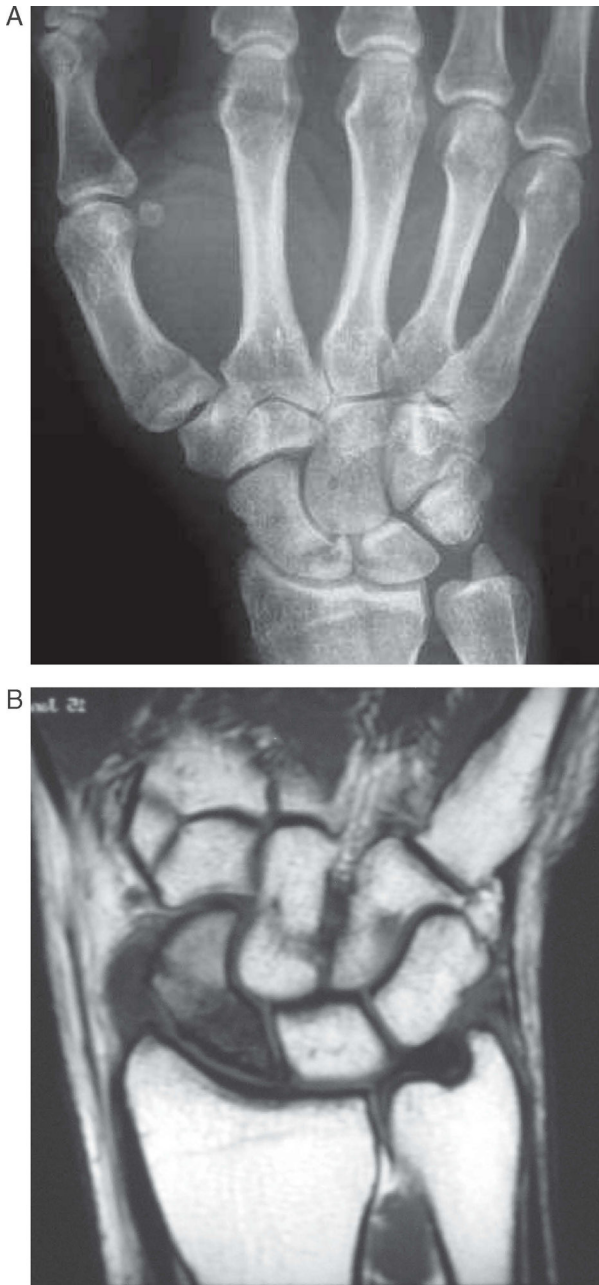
Scaphoid pseudarthrosis with proximal pole necrosis. A) PA radiological projection. B) Coronal MRI view and enhanced T1 image.
